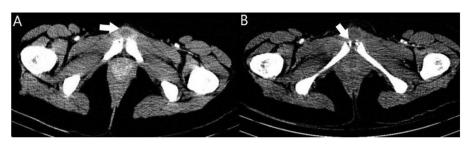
Pelvic CT with intravenous contrast revealed a collection dependent on the pubic symphysis (A), as well as bone irregularity of the adjacent pubic rami (B).
